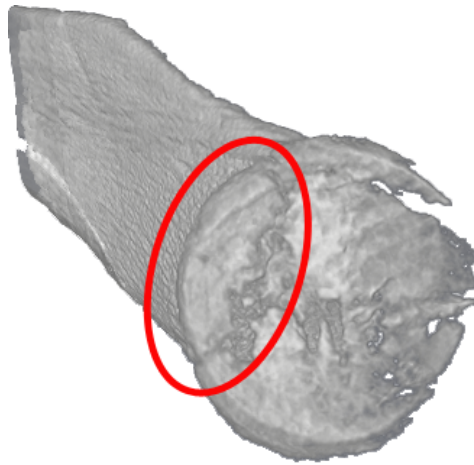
3D visualisation from CT data of a characteristic costochondral junction fracture (red oval highlights the separated rim of rib bone)
